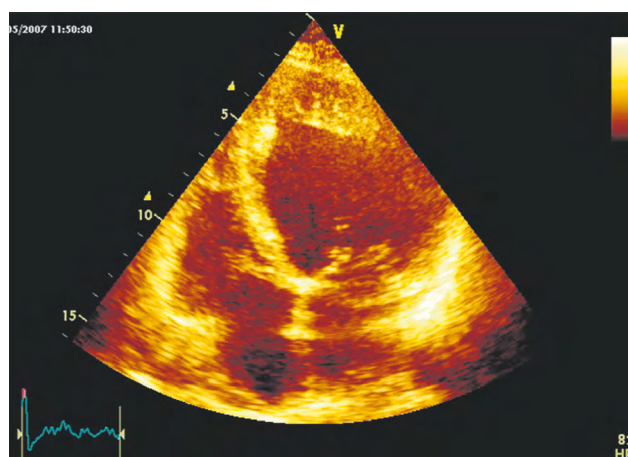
Echocardiogram of a patient with left ventricular hypertrabeculation. Apical 4-chamber view. Noteworthy is the dilatation of the left ventricle and pronounced trabecularity in the area at the apex
